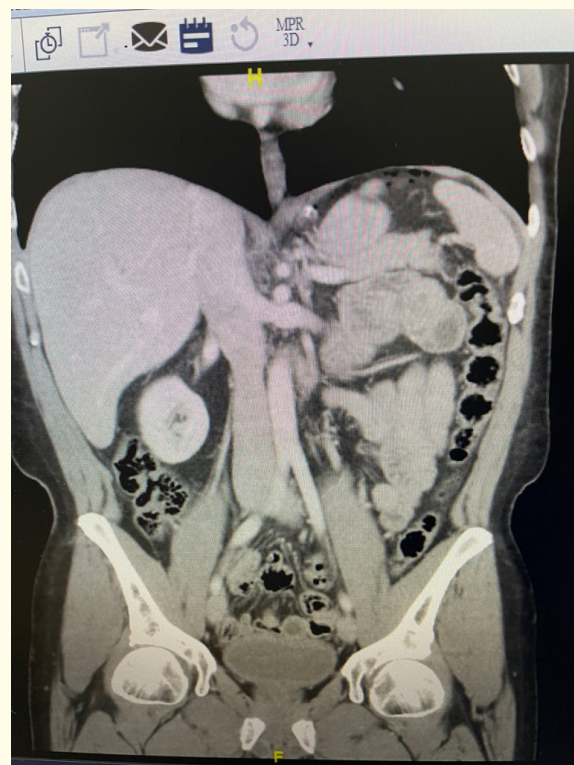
CT scan demonstrating foci of air under copula of diaphragm.
